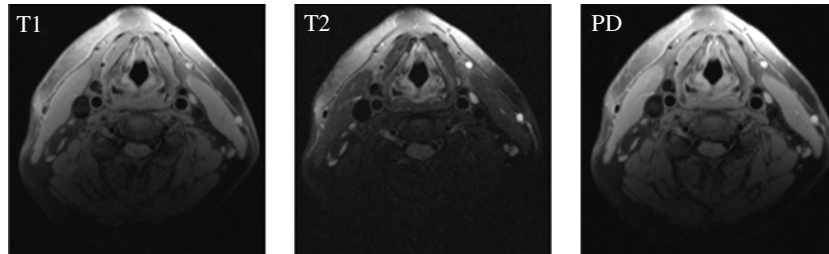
Multi-contrast T1 - T2 - PD - weighted MR images of carotid arteries.
